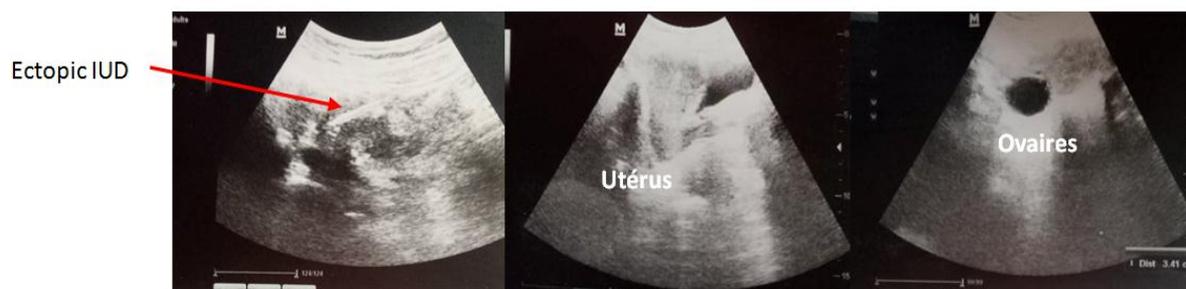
abdominal ultra-sonography showing an ectopic IUD. with normal uterus and ovaries.
